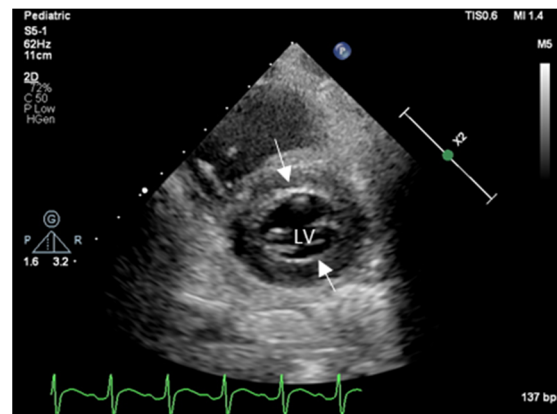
Two-Dimensional echocardiography shows a short axis of LV with increased wall thickness due to edema and inflammation immediately after heart transplantation; arrows point to thickened interventricular septum, and LV posterior wall thickness increased (z score + 2).
